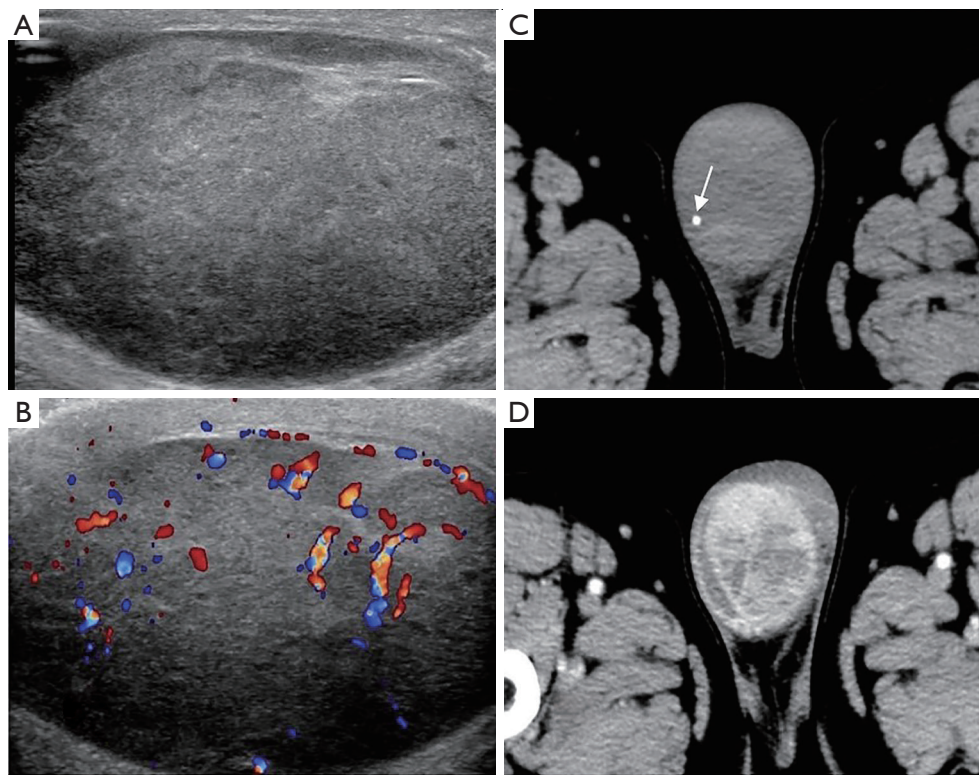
A 44-year-old male manifested with right side painful scrotum mass for 2 months. (A) Sonogram of the right hemiscrotum shows enlarged heterogeneously hypoechoic testis with small cysts. (B) CDFI shows streak blood stream signals in the enlarged testis. (C) Punctate calcification is observed in the lesion (arrow). (D) The lesion presents part range low density regions and uneven significant enhancement. CDFI, color Doppler flow imaging.
